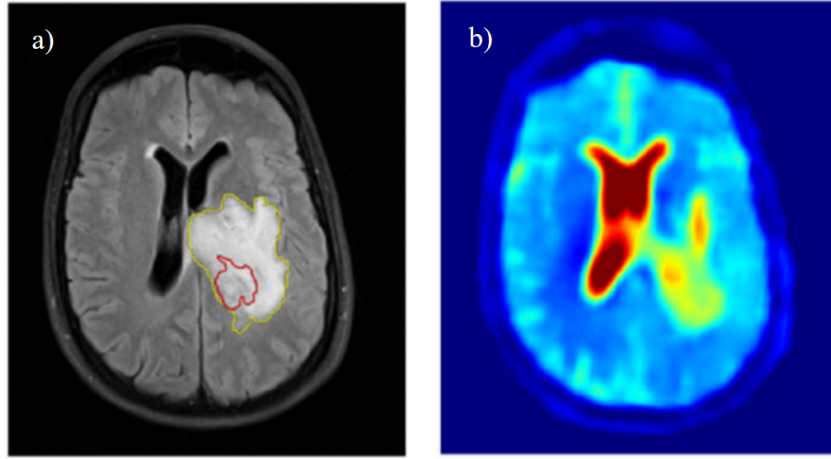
Brain tumor imaging example: a) T_2 -weighted FLAIR imaging after application of Gadolinium-based contrast agent and b) ^{23}Na MRI.
